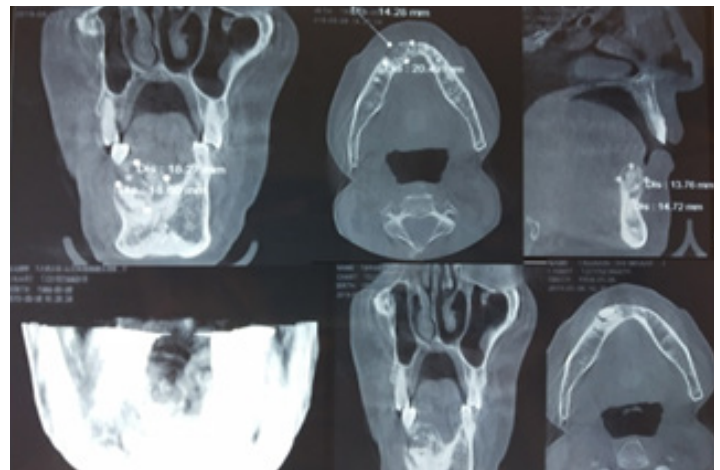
CBCT of the lesion.
